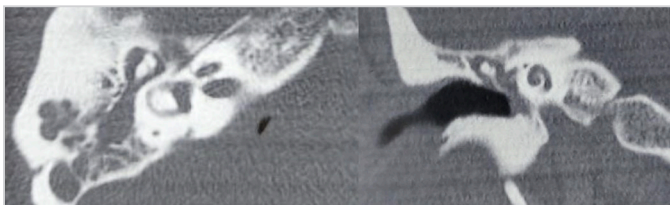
Axial and coronal computed tomography scan of the patient showing soft tissue density lesion in the middle ear, the aditus and the mastoid antrum
